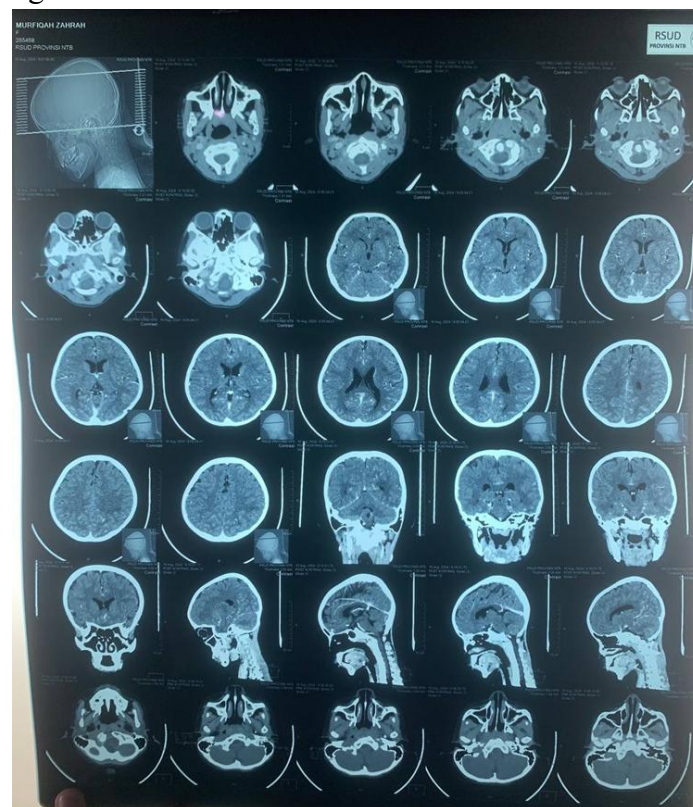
CT-scan results
